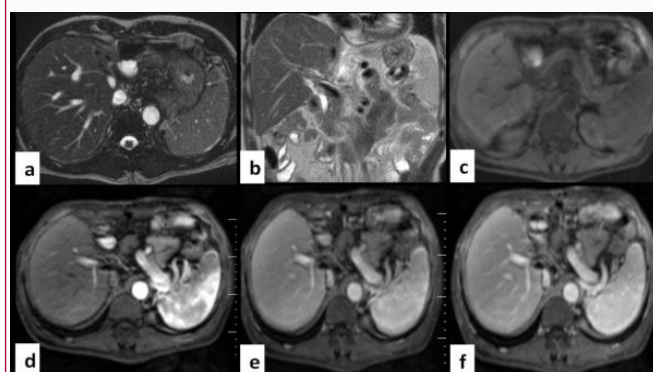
Dynamic MRI abdomen findings: Post liver transplantation images show normal appearance on axial T2 (a) and coronal T2 (b) images. No enhancing lesion is seen in liver on dynamic pre-contrast T1 (c), arterial (d), portal venous (e) and delayed phase (f).
